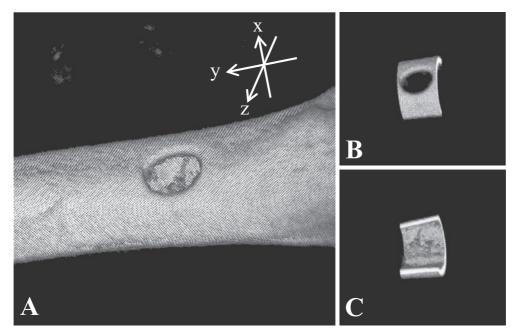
An image obtained by Micro CT A is a 3D reconstructed bone image. B shows the analyzed area including the bone defect. C is the other side of B.
